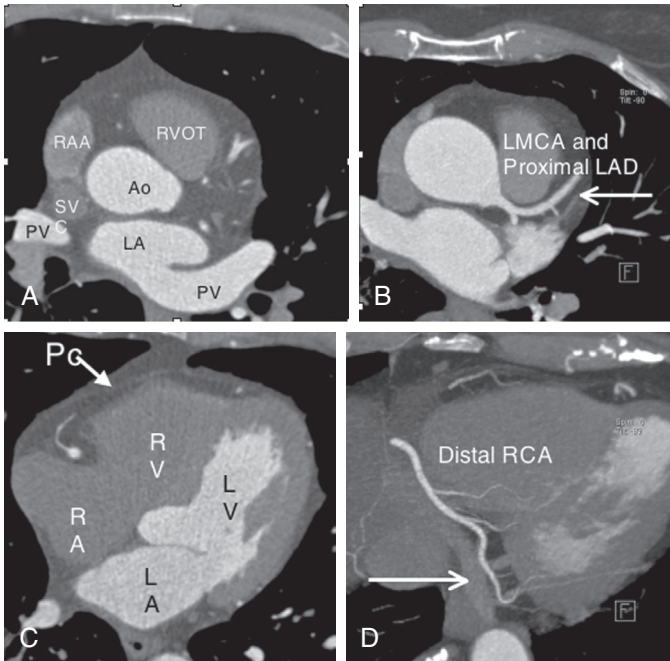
Overview of cardiac CT cross-sectional anatomy from axial images. A, Thin-slice axial projection at the level of the superior vena cava (SVC) and RV outflow tract (RVOT) showing relationships of the structures at the base of the heart. B, Thick-slice axial maximum-intensity projection showing the origin of the left main coronary artery (LMCA) and the left anterior descending coronary artery (LAD) (arrow). C, Midlevel four-chamber ventricular view showing the RA, RV, LA, and LV and the normal pericardium (Pc) (arrow). D, Thick-slice maximum-intensity projection showing the distal right coronary artery (RCA) and the nearby coronary sinus (arrow). Ao = aorta; LA = left atrium; LV = left ventricle; PV = pulmonary vein; RA = right atrium; RAA = right atrial appendage.
